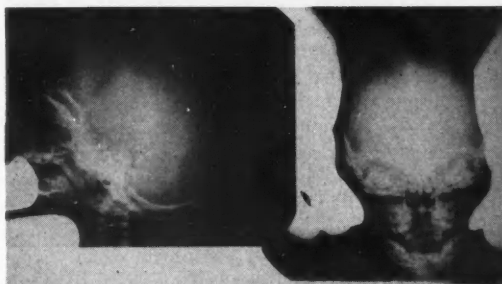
Preoperative roentgenograms of a 10-month-old boy with early skull deformity and slight developmental retardation associated with premature closure of the sagittal suture.
